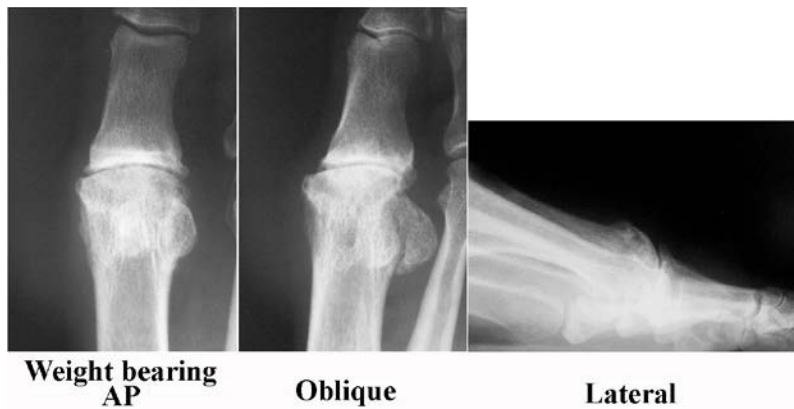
Radiographs demonstrating good agreement case for Grade 3 hallux rigidus.
